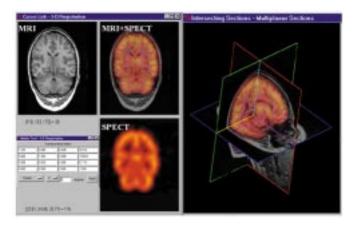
3-D registration of MRI and SPECT scans using Analyze, showing original and fused image sections, including intersecting fused orthogonal sections.
